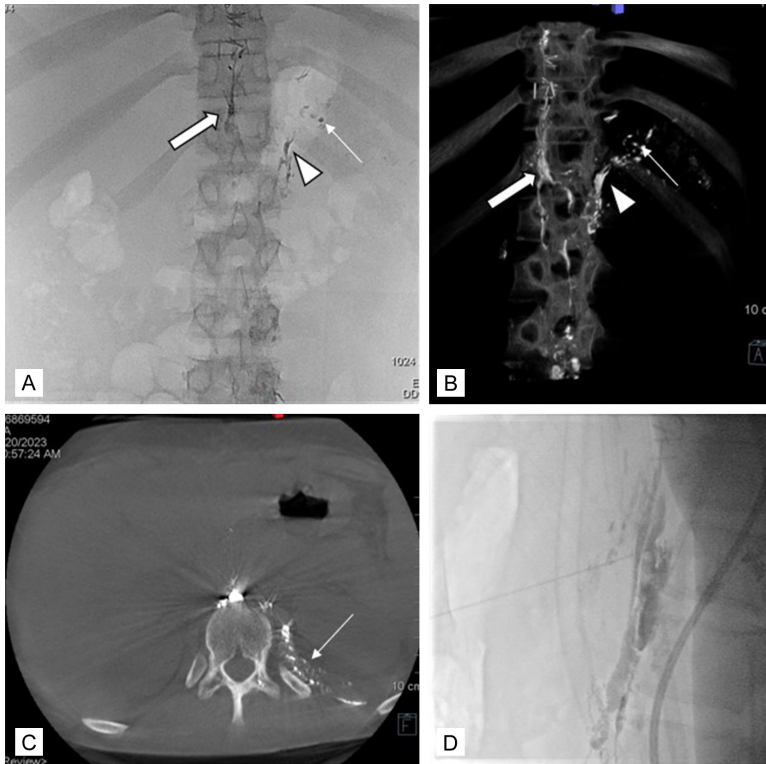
Antegrade bilateral intranodal lymphangiography from inguinal lymph nodes was tried again 3 days after thoracic duct retrograde embolization. A. Significant opacification of the cisterna chyli (arrow) at the T12 vertebrae level was seen 20 minutes after lipiodol injection from the lymph nodes in both groins. Aberrant collateral lymphatics (arrowhead) from the left lumbar lymphatics drain to the left hemithorax (thin arrow). B, C. Anatomic localization of aberrant collateral lymphatics (arrowhead), the cisterna chyli (arrow) and thoracic leakage (thin arrow) is better demonstrated in CBCT VRT and CBCT lymphangiographic source images. D. Lateral scopic image shows a mixture of lipiodol - N-butyl cyanoacrylate (NBCA) injection into the cisterna chyli with a 21-gauge Chiba needle.
